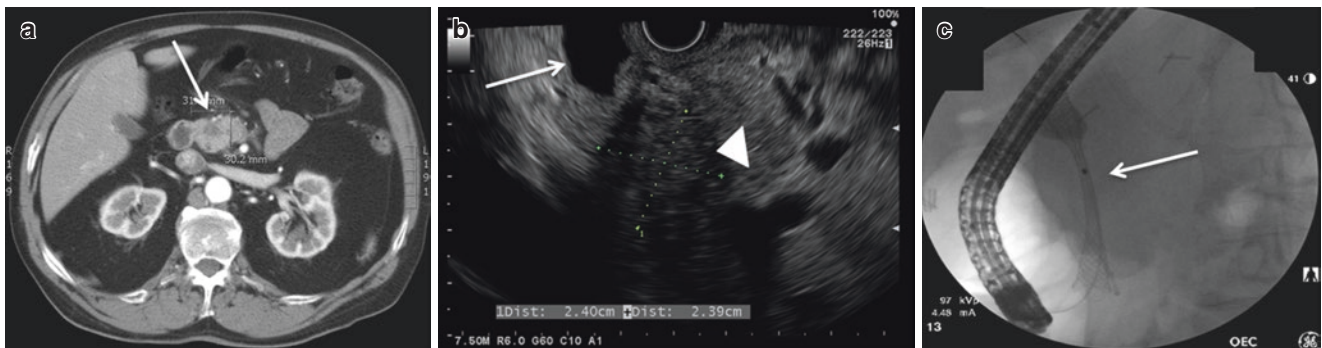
Obstructing pancreatic adenocarcinoma. (a) A 2.5-cm ill-defined lesion in the pancreatic head on CT scan; (b) pancreatic head mass (arrowhead) resulting in biliary obstruction and dilated common
